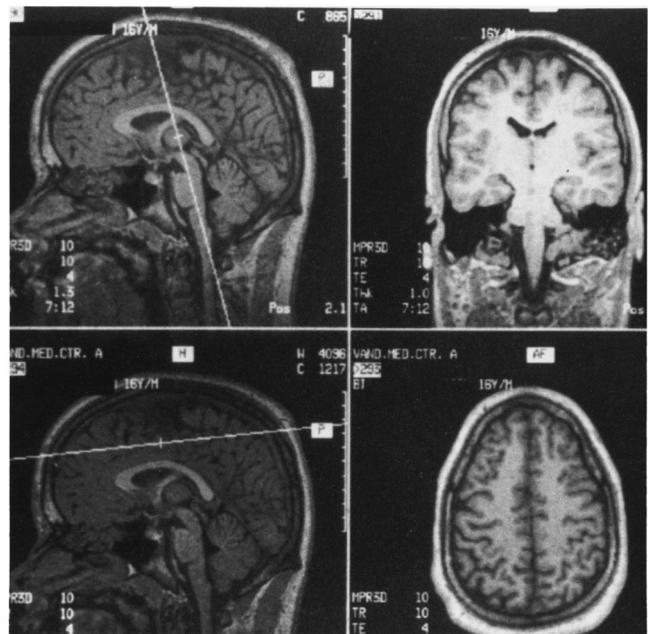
MRI anatomic images through different planes from a $128 \times 256 \times 256$ three-dimensional dataset (from Price, 1995).
